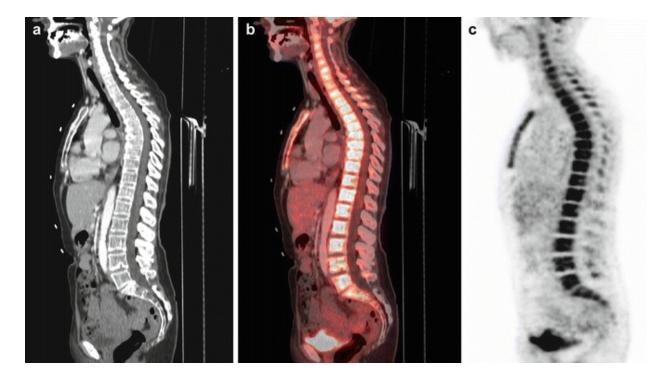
A 64-year-old female patient suffering from acute myeloid leukemia and accompanying B-cell non-Hodgkin lymphoma with biopsy-proven bone marrow infiltration undergoing PET/CT after induction chemotherapy. Supportive therapy with granulocyte colony-stimulating factor (G-CSF) was performed until 2 days before the PET/CT examination. Contrast-enhanced CT (a), fused PET/CT (b), and PET images (c) are displayed. A markedly increased tracer uptake in the bone marrow was observed. As no malignant cells were observed in bone marrow biopsy, the tracer uptake in the bone marrow was most likely induced by G-CSF therapy
